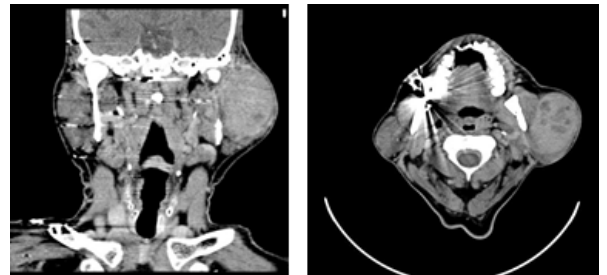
CT contrast coronal and axial images show well-defined heterogeneously enhancing soft tissue mass lesion involving superficial lobe of left parotid gland and extending up to the deep lobe with internal areas of necrosis, with abutment over masseter muscle anteriorly.
